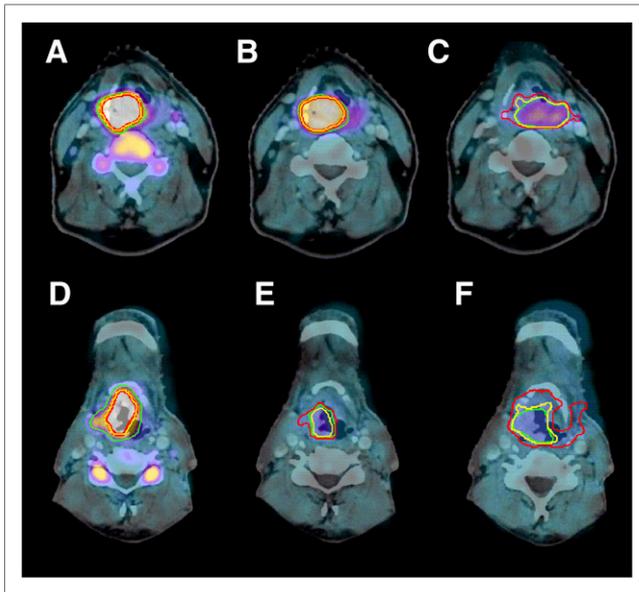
^{18}F -FLT PET/CT before therapy (A and D), in second week of therapy (B and E), and in fourth week of therapy (C and F). First example (A–C) shows slow decrease in ^{18}F -FLT uptake (cT4N2bM0 supraglottic laryngeal carcinoma treated with chemoradiotherapy; local recurrence after 7 mo; later distant metastases) and second one (D–F) fast decrease (cT3N1M0 supraglottic laryngeal carcinoma treated with radiotherapy only; no tumor-related event after 32 mo of follow-up). For GTV_{VIS} (green), 3-dimensional volume change was +8% between A and B, –35% between A and C, –60% between D and E, and –66% between D and F. For GTV_{SBR} (yellow), 3-dimensional volume change was +7% between A and B, +4% between A and C, –44% between D and E, and +22% between D and F. For $\text{GTV}_{50\%}$ (red), 3-dimensional volume change was +11% between A and B, +102% between A and C; +30% between D and E, and +247% between D and F. $\text{SUV}_{\text{max}(9)}$ changed by –35% between A and B, –70% between A and C, –58% between D and E, and –69% between D and F.
